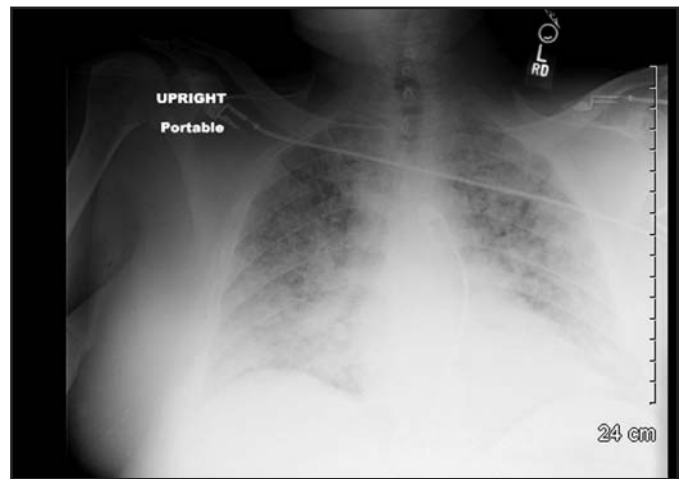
Bilateral pulmonary infiltrates revealed by chest radiograph
